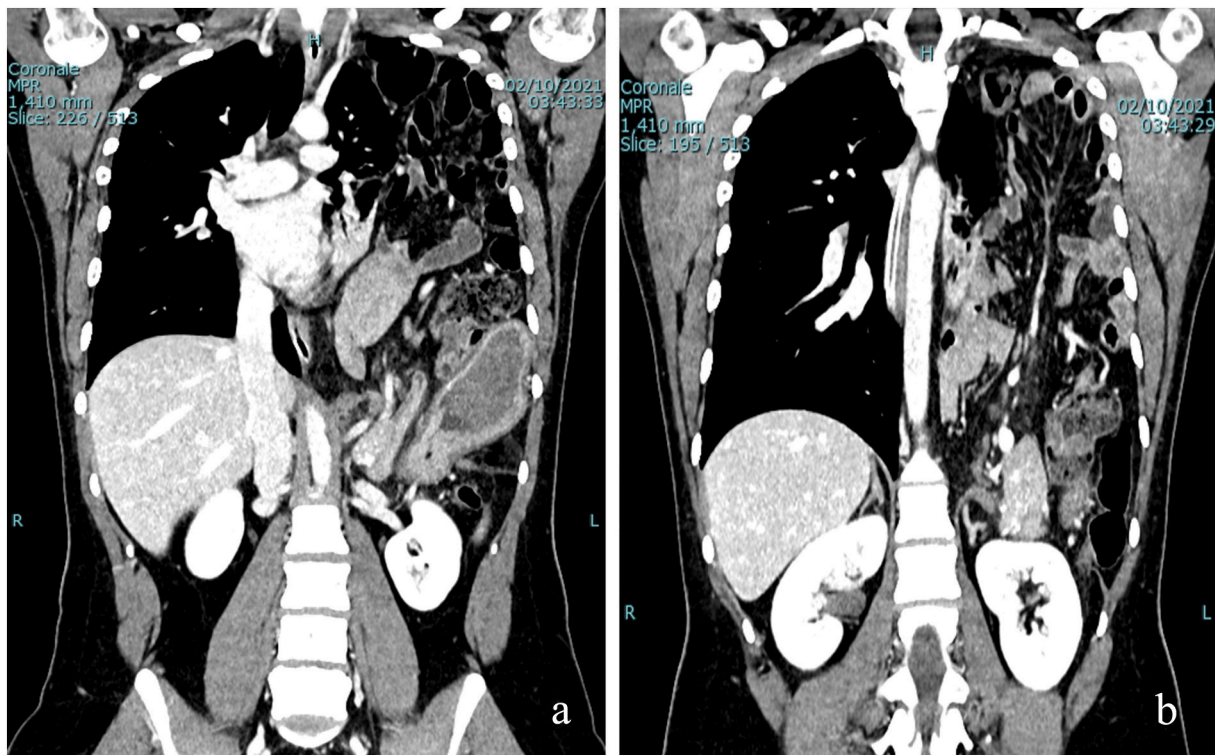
Coronal CT-scan images demonstrating the giant left-sided hernia defect.
